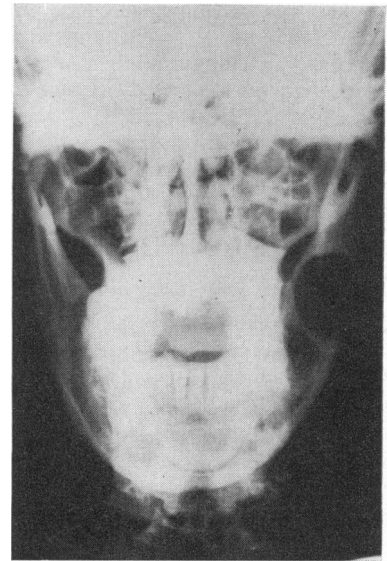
Radiograph of advance adamantinoma with associated pathological fracture of the left mandible
